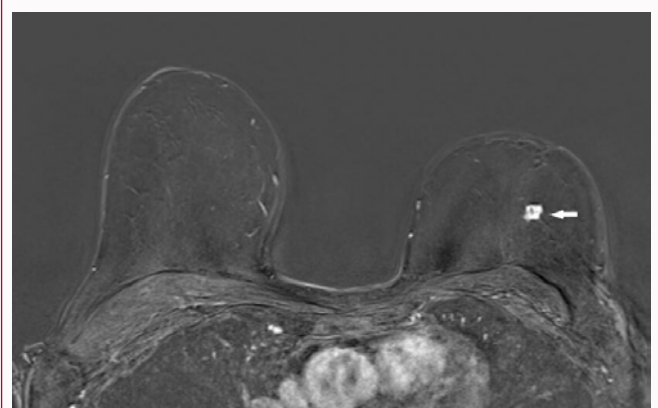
a). Contrast-enhanced MR image: heterogeneous enhancement with intralesional cystic-necrotic changes. b). Apparent Diffusion Coefficient (ADC) map: Lesion is hyperintense indicating no restricted diffusion.
